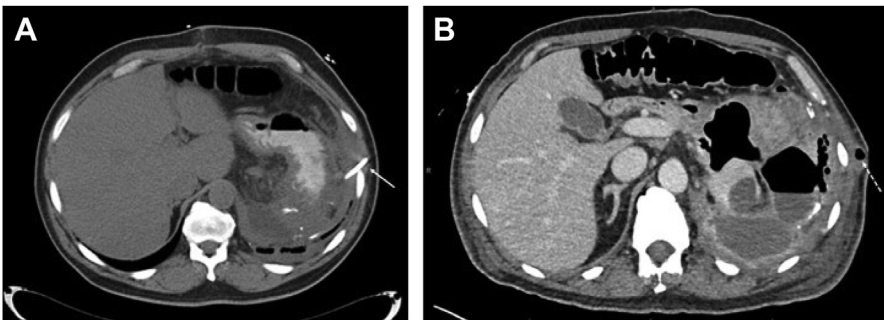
Computed tomogram of the abdomen showing a percutaneous drain (solid arrow) into a WON (A). A pancreaticocutaneous fistula (dotted arrow) was observed (subcutaneous air bubble) on follow-up imaging (B).
